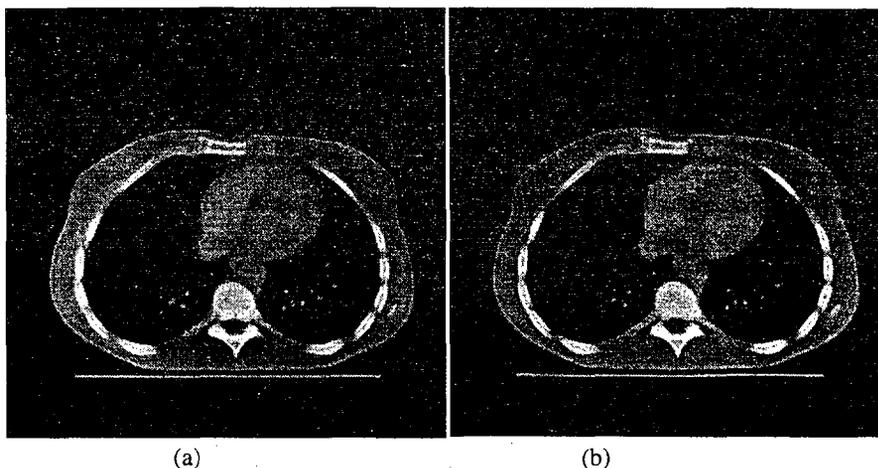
A CT slice through the abdomen of a patient with a pancreas carcinoma: (a) original picture (512*512 pixels) and (b) "compressed" picture (33,800 pixels of different sizes)
